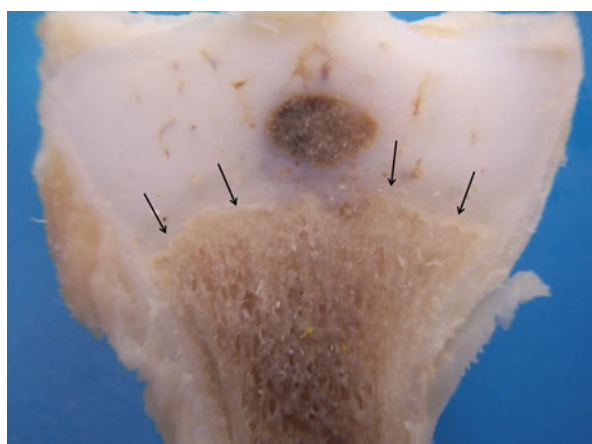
Gross appearance of a proximal tibia CML from the radiograph in [Fig. 15.26](#). Note the ragged, moth-eaten appearance of the metaphysis (*arrows*) compared to the normal metaphysis in [Fig. 15.20](#)
